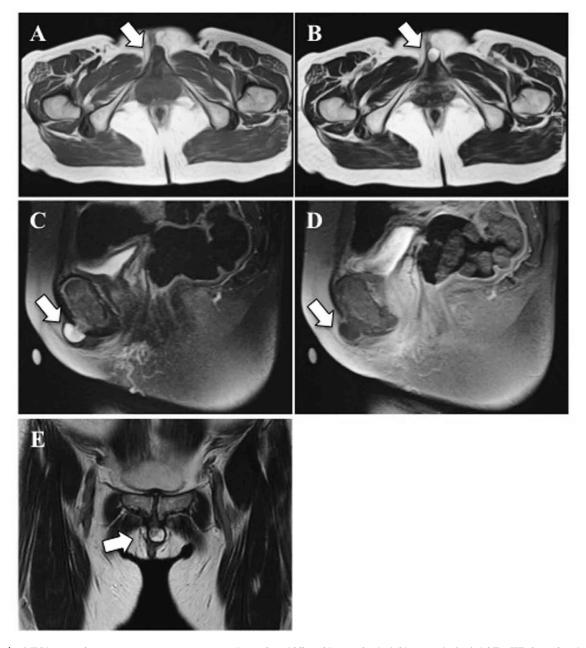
MRI images show a  $1.5 \times 1.0 \times 1.0$  cm mass anterior to the middle pubic symphysis (white arrow). A: Axial T1-WI shows low-intensity attenuation; B: axial T2-WI and C: sagittal STIR images show high-intensity attenuation; D: sagittal contrast-enhanced MRI showing no gadolinium enhancement of the tumor except for peripheral lesion; E. coronal T2-WI.
